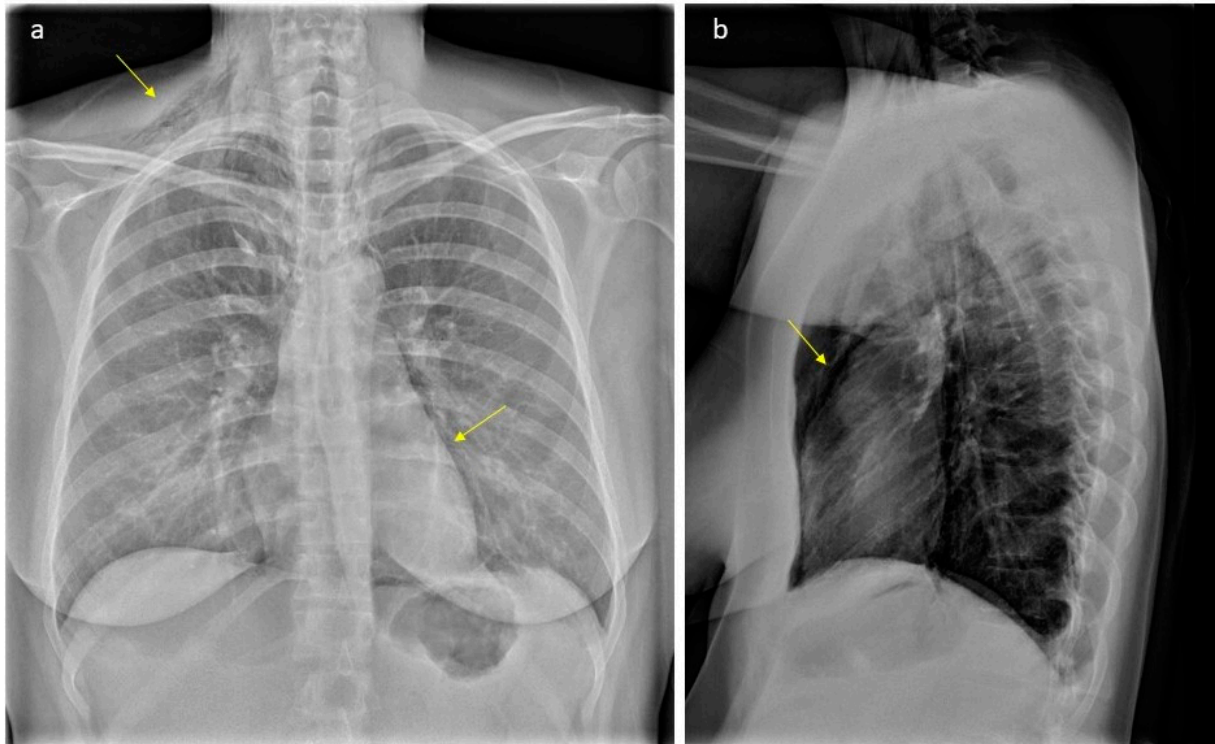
Plain radiograph scan showing typical gas accumulations seen subcutaneous and with pneumomediastinum (arrows, part A): There is significant subcutaneous emphysema, more pronounced on the right side (arrow, part A). We can see an outlining of the pericardium both in lateral projection (arrow, part B) and with «continuous diaphragm sign» on frontal projection (arrow, part A). You can also see continuous lucencies along upper mediastinum to the neck, through upper thoracic aperture.
